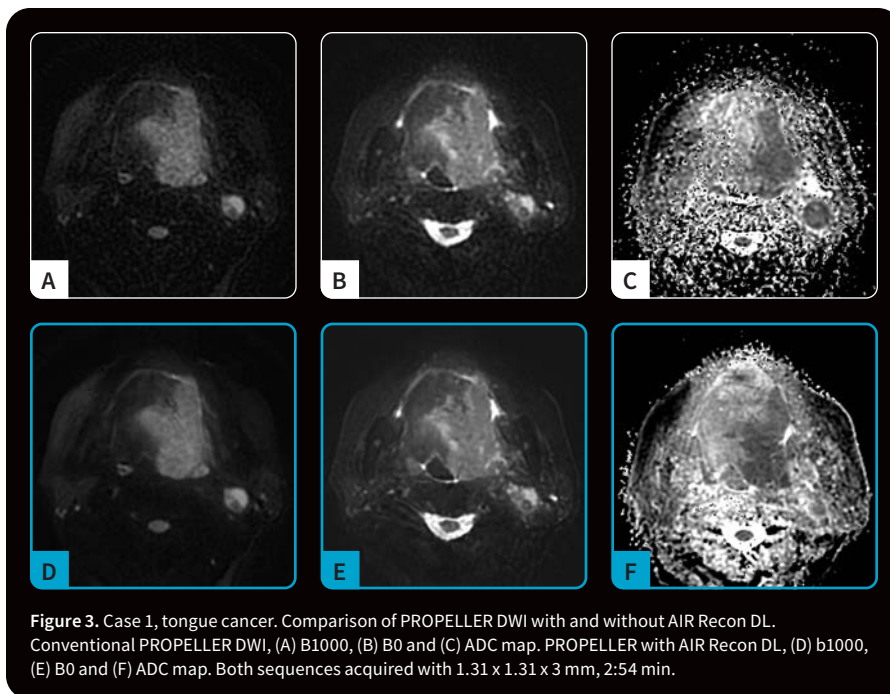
Case 1, tongue cancer. Comparison of PROPELLER DWI with and without AIR Recon DL. Conventional PROPELLER DWI, (A) B1000, (B) B0 and (C) ADC map. PROPELLER with AIR Recon DL, (D) b1000, (E) B0 and (F) ADC map. Both sequences acquired with 1.31 x 1.31 x 3 mm, 2:54 min.
